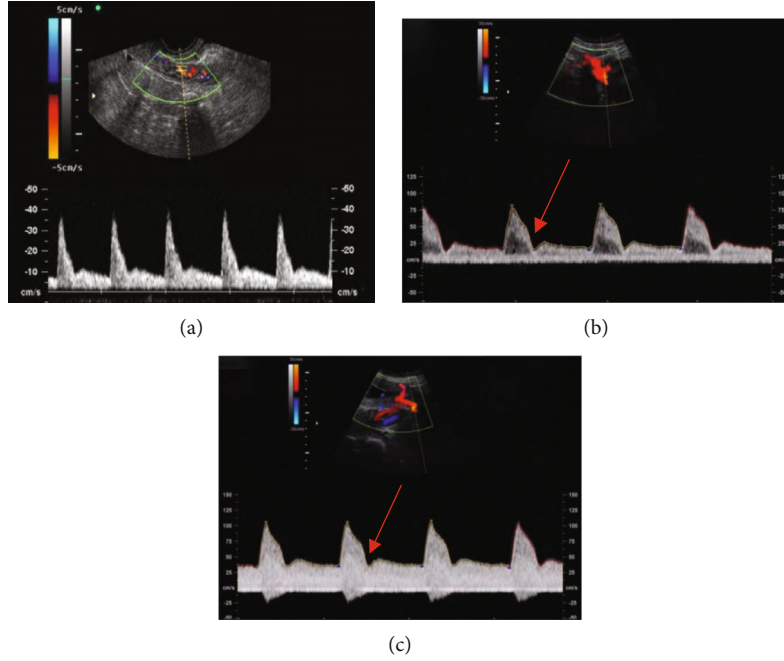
The blood flow spectra of fetal UtA. (a) Doppler waveform of UtA blood flow of pregnant women measured by transabdominal ultrasound in the control group. (b) Doppler waveform of abnormal UtA blood flow in the mild group. (c) Doppler waveform of abnormal UtA blood flow in the severe group. The red arrow indicated the diastolic notch.
